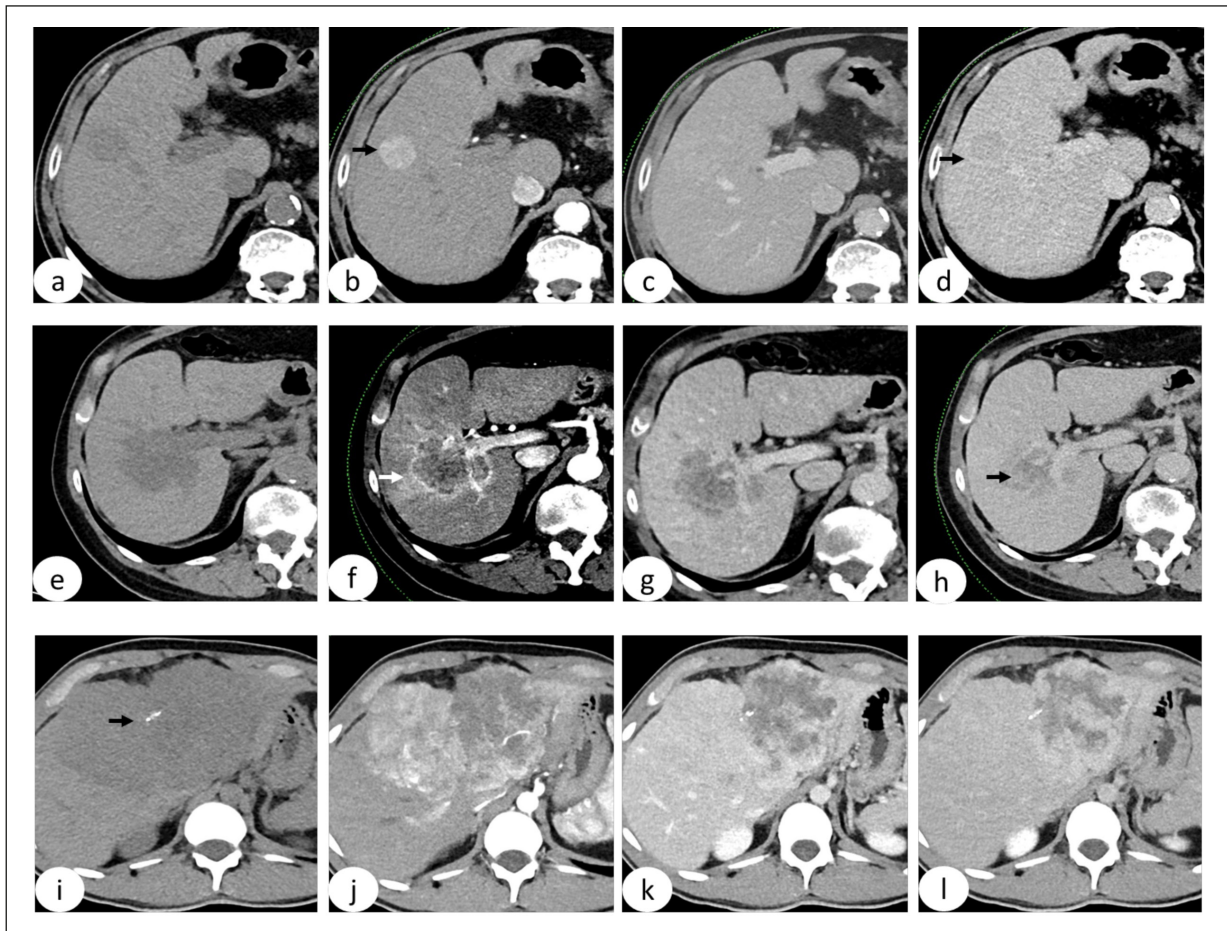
Hepatocellular Carcinoma [HCC, (a-d)], Intrahepatic Cholangiocellular Carcinoma [iCCC, (e-h)], Fibrolamellar HCC on CT (i-l). a,e,i, Basal acquisition, (b,f,j) late arterial, (c,g,k) portal venous, d,h,l: late phases. HCC shows the typical *nonrim APHE* [arrow in (b)], with *washout* on the late phase [arrow in (d)]. iCCC shows the *rim APHE* [arrow in (f)] with a delayed enhancement of the central fibrous component [arrow in (h)], describing a *targetoid appearance*. Fibrolamellar HCC shows calcification at basal acquisition [arrow in (i)], with heterogeneous APHE and washout (j-l).
